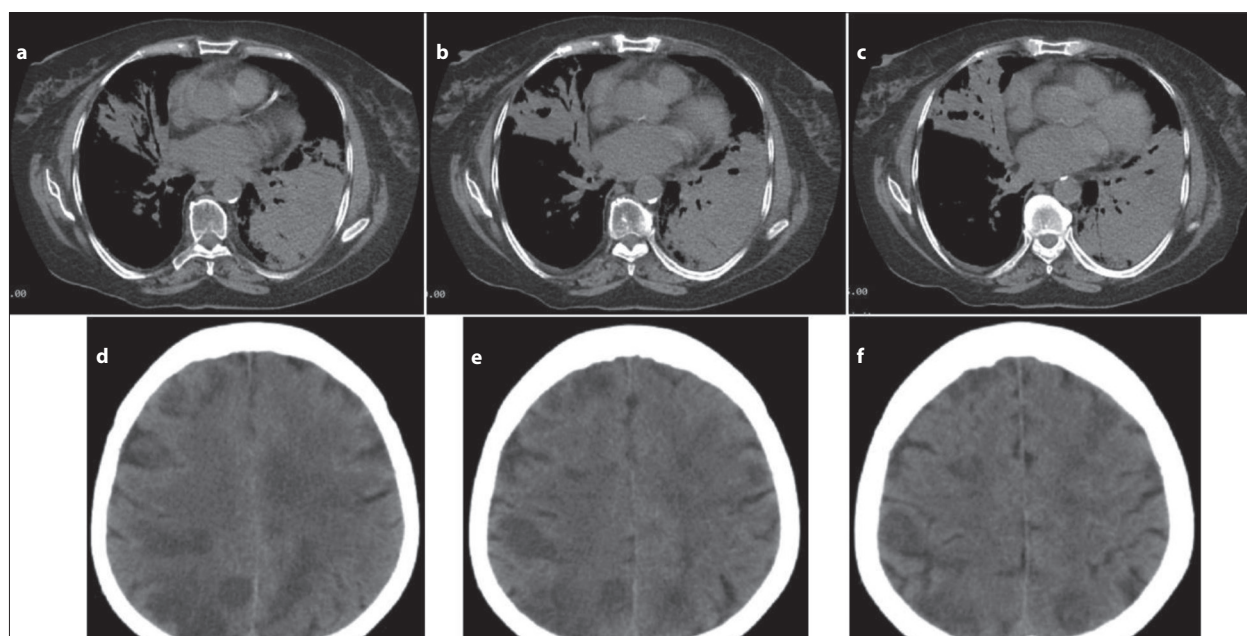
a, b, c – thoracic computed tomography scan showed generalized, partially necrotized inflammatory consolidation of distal part of left lower lobe with signs of numerous cavities of different size, on the right lung with partially necrotized inflammatory infiltrates with signs of cavities within; d, e, f – computed tomography scan of head showing multiple inflammatory lesions through the brain some of which forming abscesses up to 34 mm in diameter
